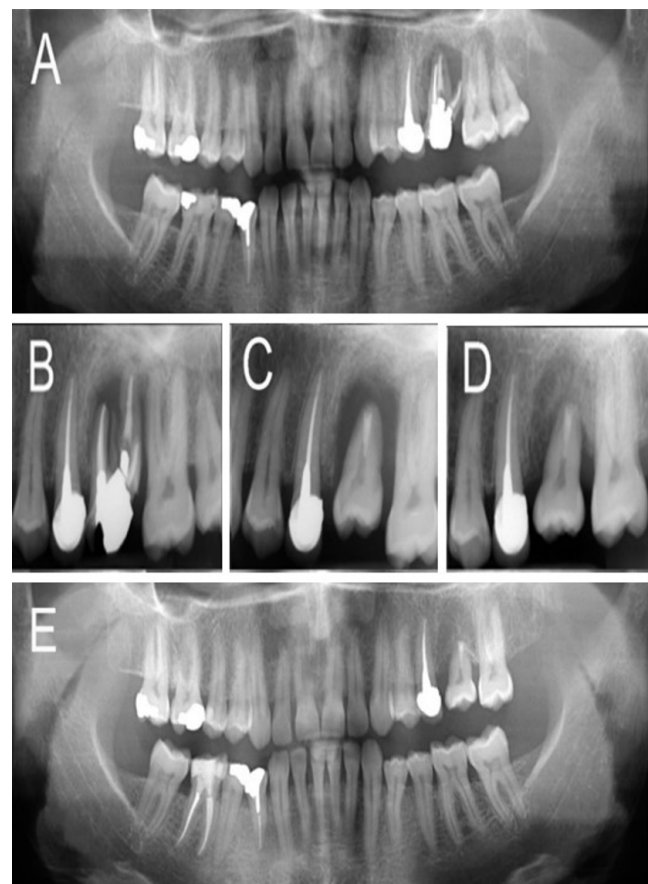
Sequential radiographic documentation of the autogenous tooth transplantation (ATT) case. A: Initial orthopantomogram (OPG) demonstrates a severely compromised upper left first molar showing a vertical root fracture (VRF) associated with a huge wraparound endodontic-periodontic lesion. The adjacent maxillary wisdom, with a fully developed root/apex and no opposing tooth, appears healthy/suitable as a donor tooth. B: Pre-op periapical radiograph reveals the fracture pattern and advanced bone destruction surrounding the first molar's roots, deciding on tooth extraction and replacement via ATT. C: The immediate post-operative radiograph shows the donor tooth positioned within the socket of the extracted first molar. The single root-end cavity has been retrogradely filled/sealed with calcium-enriched mixture cement to provide a tight seal and promote periodontal regeneration. D: Two-year follow-up periapical radiograph shows substantial bone healing of the alveolar defect; the transplanted tooth shows no radiographic signs of root resorption or ankylosis, with a visible periodontal ligament space (thin radiolucent line). E: At the three-year recall, the OPG confirms that the bone remains stable and there is a harmonious occlusal relationship. It is important to note that the bone level is still slightly below the cemento-enamel junction. This is due to a residual defect from the original VRF lesion, as well as the typical anatomical position of a mature third molar.
